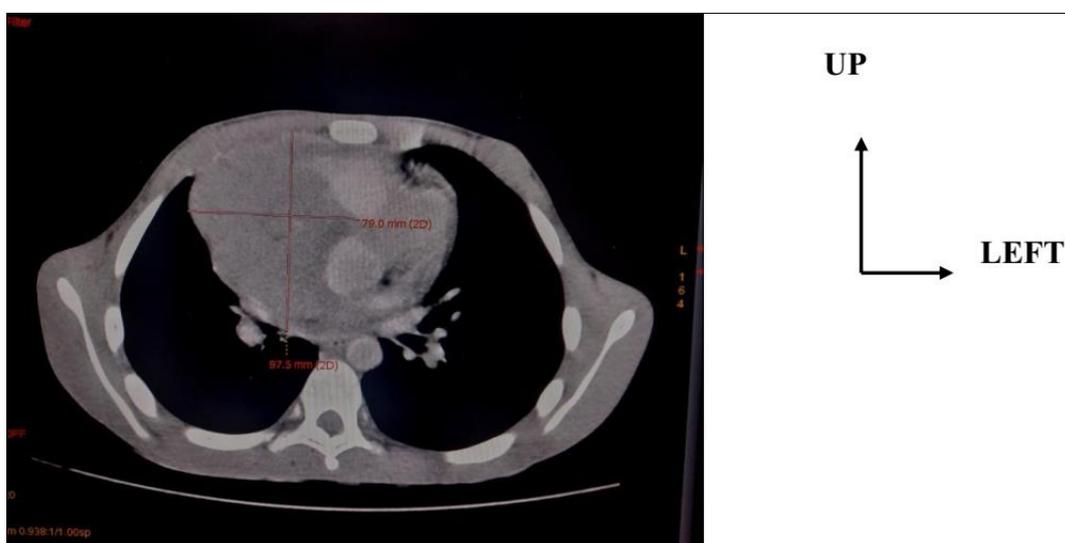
Axial CT + injection section showing a tissue mass of the right cardiac chambers, hypodense, with irregular contours with heterogeneous enhancement
